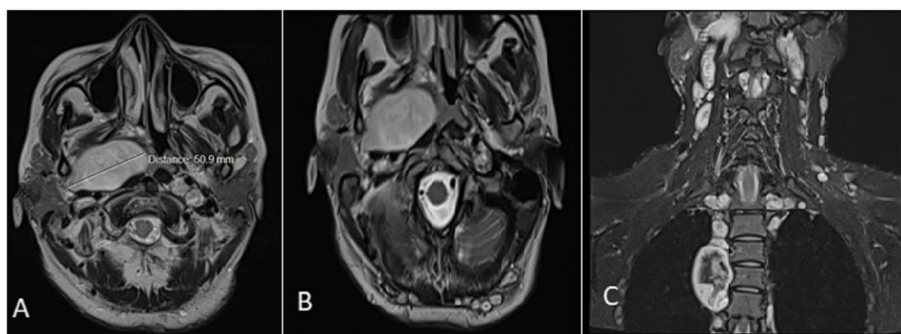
A is T2 weighted and [B] is T1 weighted CE-MRI of neck in axial cut showing tumor of $5 \times 4.8 \times 4.6$ cm in right parapharyngeal space causing narrowing of nasopharynx and oropharynx. C is a T1-weighted CE-MRI of neck and cervical spine in coronal cut showing multiple enhancing ovoid/rounded paraspinal SOLs seen throughout the spine. Also showing multiple subcutaneous nodules in neck and chest walls. All these are suggestive of neurofibromas
